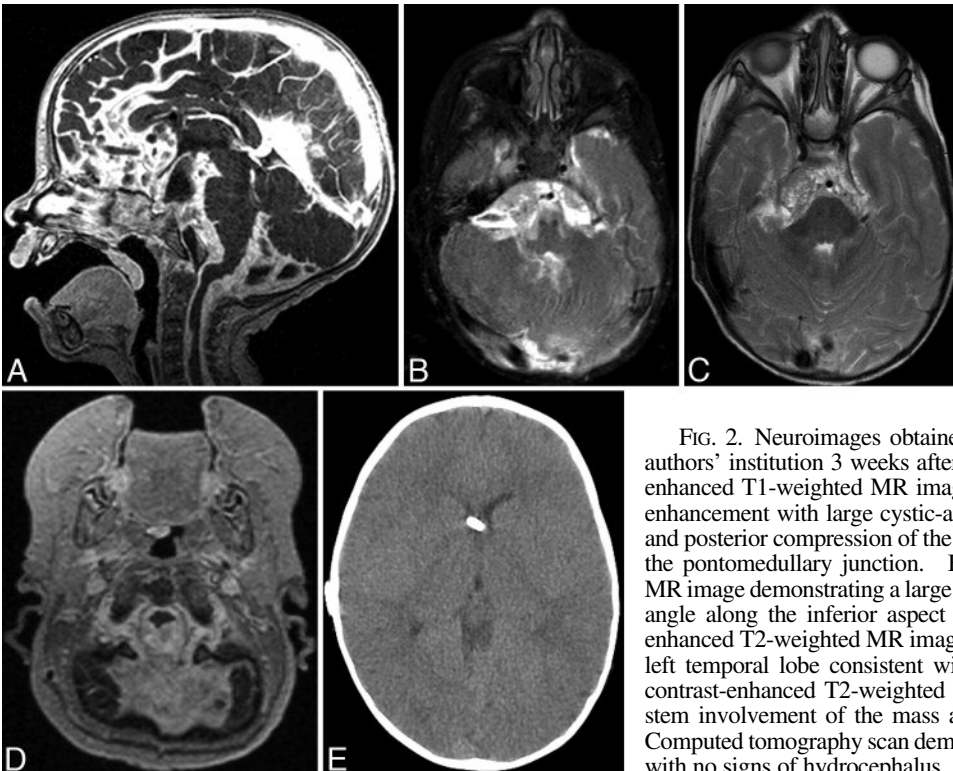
Neuroimages obtained upon the patient's presentation to the authors' institution 3 weeks after shunt placement. *A:* Sagittal contrast-enhanced T1-weighted MR image demonstrating diffuse leptomeningeal enhancement with large cystic-appearing masses associated with anterior and posterior compression of the pons, medulla, and upper cervical cord at the pontomedullary junction. *B:* Axial contrast-enhanced T1-weighted MR image demonstrating a large mass involving the right cerebellopontine angle along the inferior aspect of the frontal lobe. *C:* Axial contrast-enhanced T2-weighted MR image demonstrating a hyperdense area of the left temporal lobe consistent with melanocyte pigmentation. *D:* Axial contrast-enhanced T2-weighted FLAIR MR image demonstrating brainstem involvement of the mass at the level of surgical intervention. *E:* Computed tomography scan demonstrating optimal placement of VP shunt with no signs of hydrocephalus.
